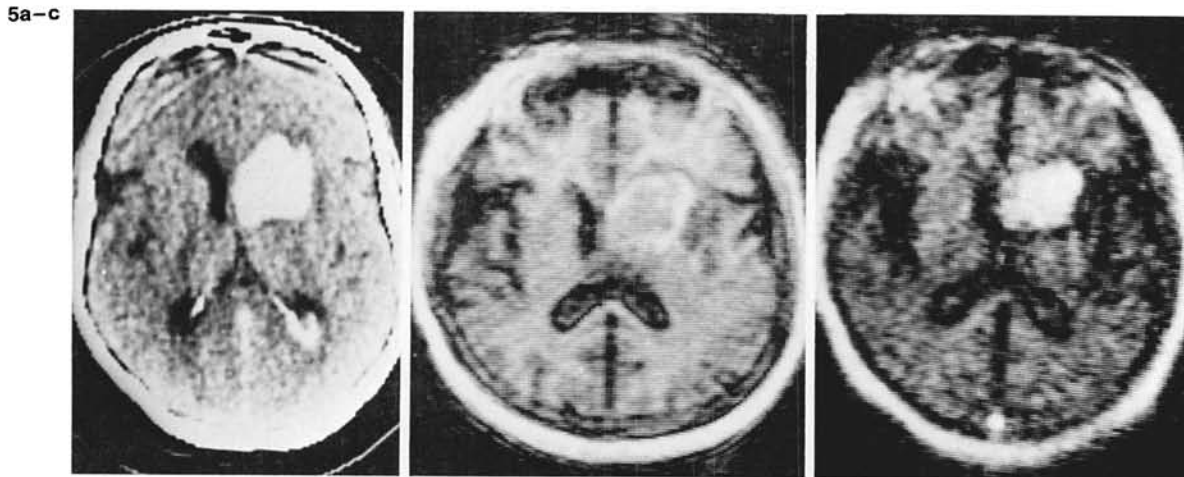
A 10-day-old intracerebral hematoma is shown on noncontrast CT scan (a), with inversion recovery (IR) 1,500(400)/30 at 0.17 T (b) and with IR 1,000(200)/70 at 0.02 T (c). The difference in visualization of the same lesion in the T1 weighted images at 0.17 and 0.02 T is demonstrated.
